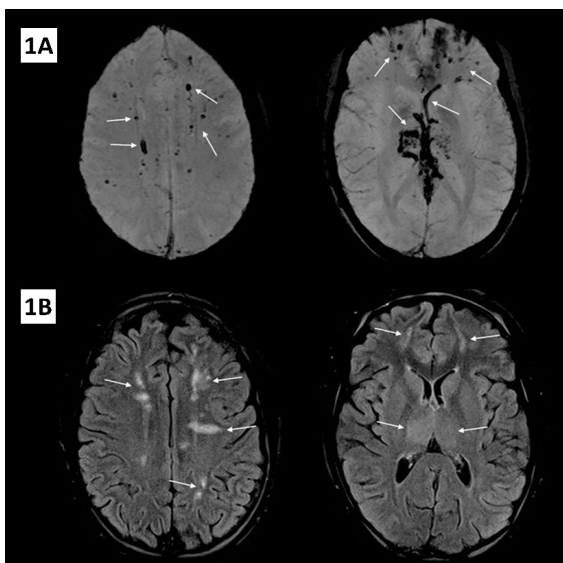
The arrows show cerebral thrombosis and microhemorrhages in gradient echo sequences (1A) and in FLAIR sequences (1B).
